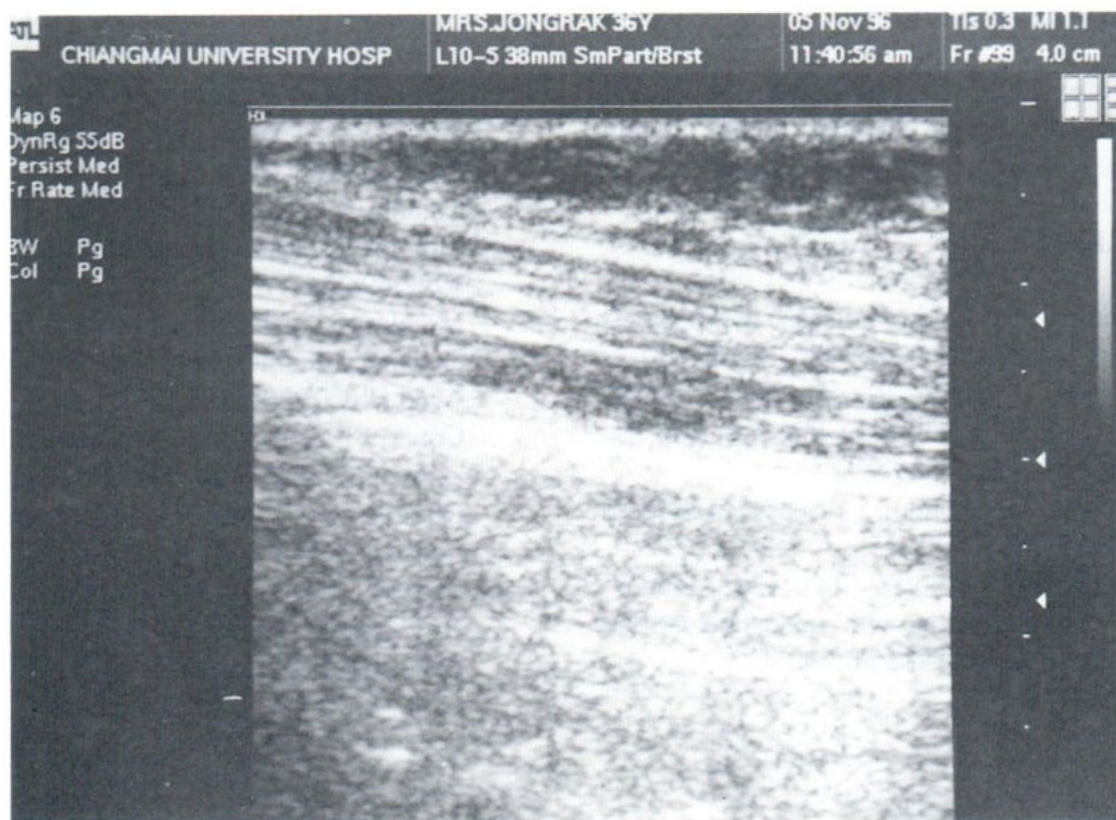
Sonogram shows a hypoechoic tubular structure.
